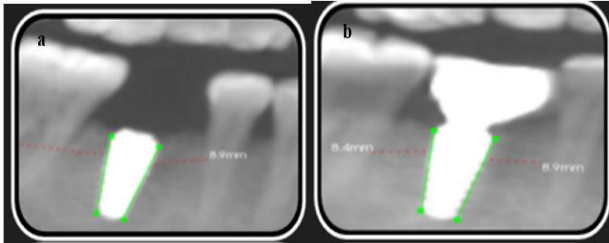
(a) Measuring crestal bone level on mesial and distal aspect of implant at baseline (immediately after implant placement) through CBCT, (b) measuring crestal bone levels on mesial and distal aspect of implant at 9 months of placement through CBCT.
